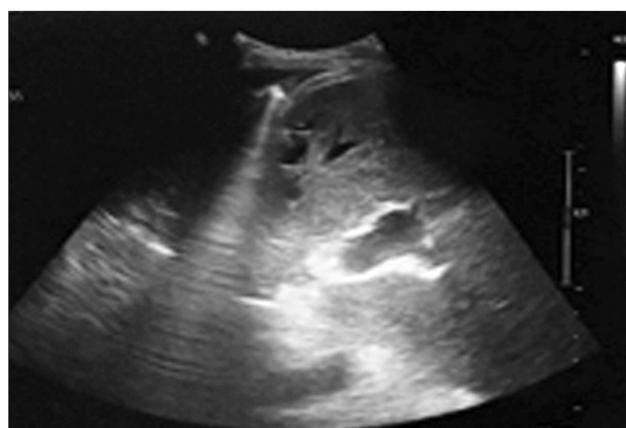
Ultrasound examination - no more perihepatic collection (September 2022)
